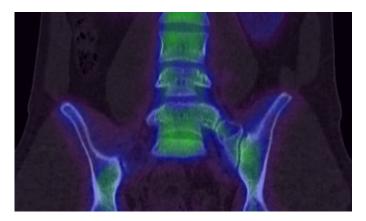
Four years postoperative: SPECT scan with absence of captation at left L5-S1 LSTV.
